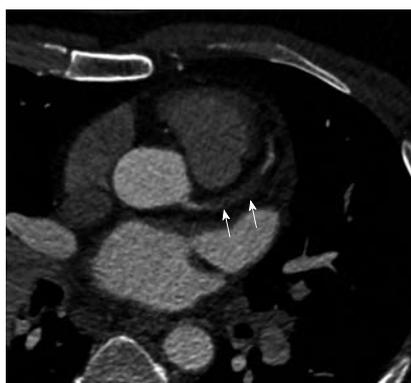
Coronary computed tomography angiography in a 43-year-old male presenting with chest pain and raised cardiac enzymes shows non-calcified plaque at the left main and left anterior descending arteries (arrows) causing a complete total occlusion of these vessels.
